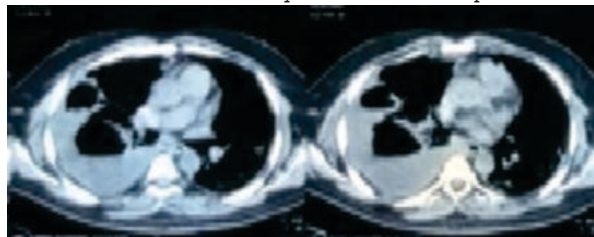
CT Chest Showing Multiple Cavities In Right Lung.
